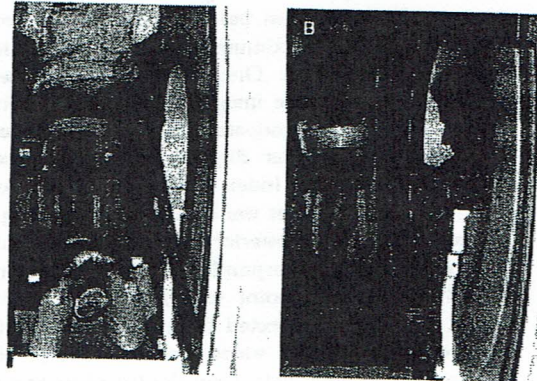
Weight-bearing and non-weight-bearing movements inside the vertically open, magnetic resonance imaging system. (A) Non-weight-bearing knee extension against 5% of body weight. (B) Weight-bearing single-limb squat. The flexible surface coil surrounding the knee did not restrict or influence knee motion.
